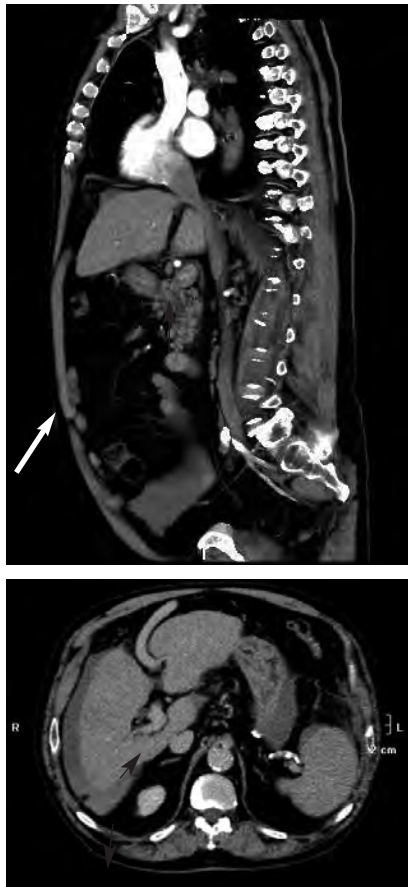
Thoracoabdominal CT scan showing a dilated umbilical varicose vein (arrow).
